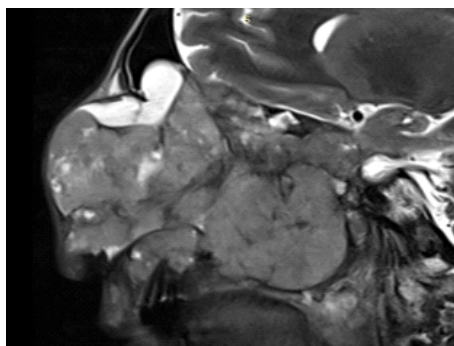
Sagittal T2 MRI showing well defined isointense mass in left nasal cavity extending into sphenoid sinus, without brain parenchymal extension into the frontal lobe.
